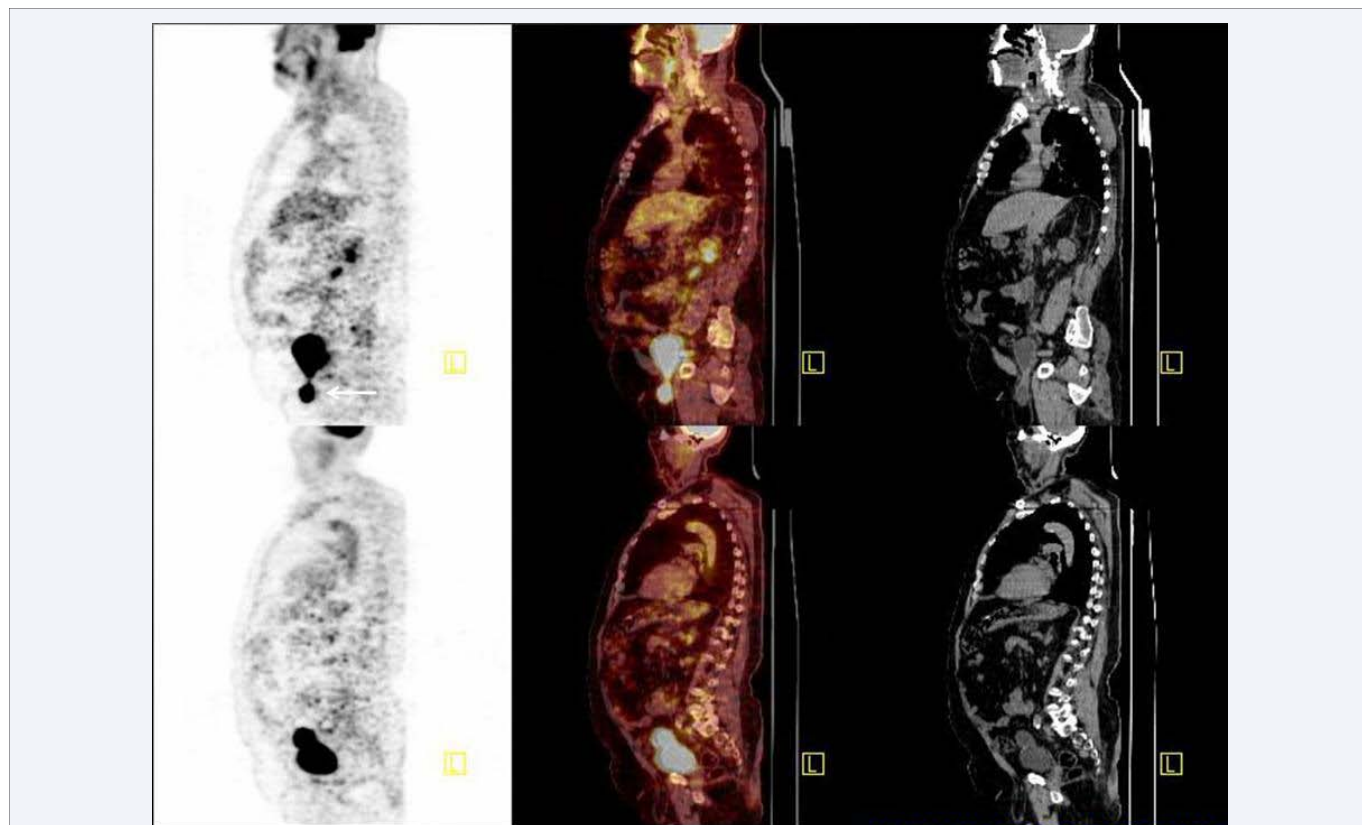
Sagittal PET, PET/CT fusion and CT images show urinary bladder diverticulum in inguinal hernia sac (arrows). Urinary bladder and bladder diverticulum are joined by a bridge of moderate increased FDG activity.
